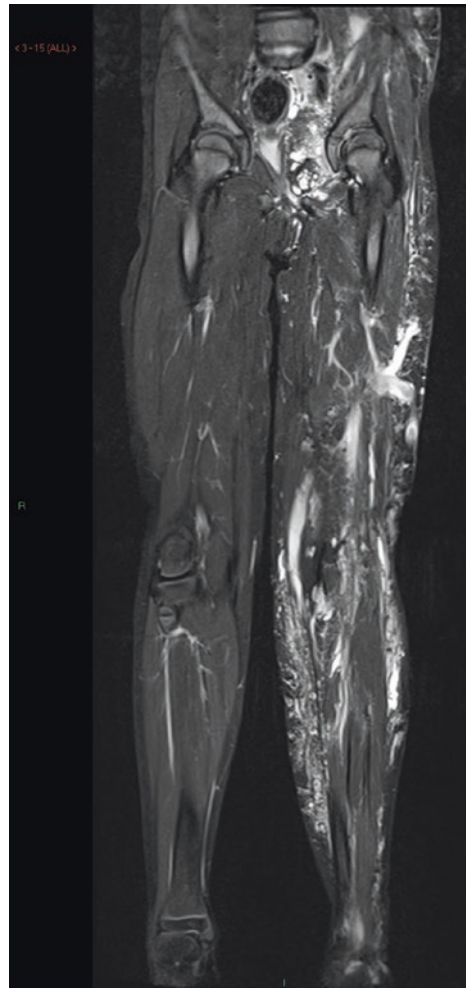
MRI of the same child demonstrates widespread low-flow malformation of the left lower limb
